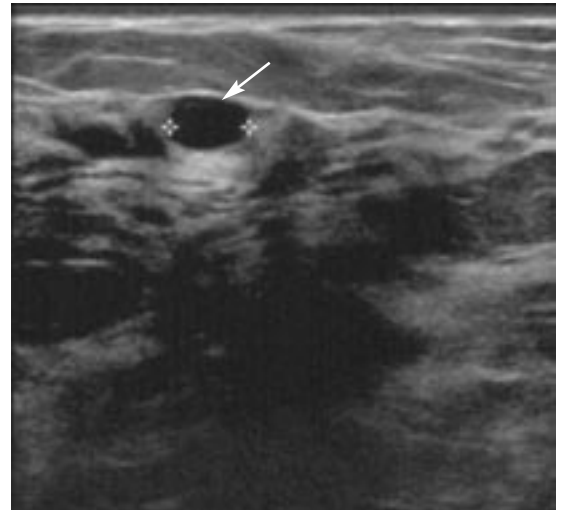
Ultrasonography further defines the mass (arrow) as a simple cyst.
